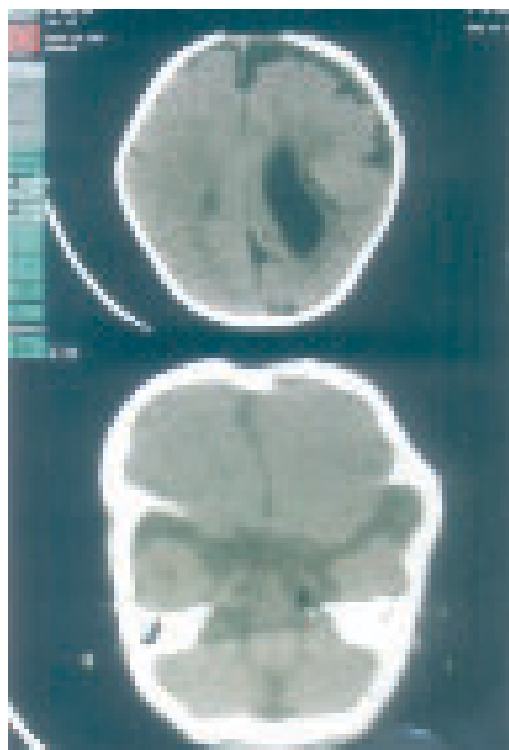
CT scan depicts dilated left lateral ventricle with lipoma (arrowhead) at left cerebello-pontine angle.
